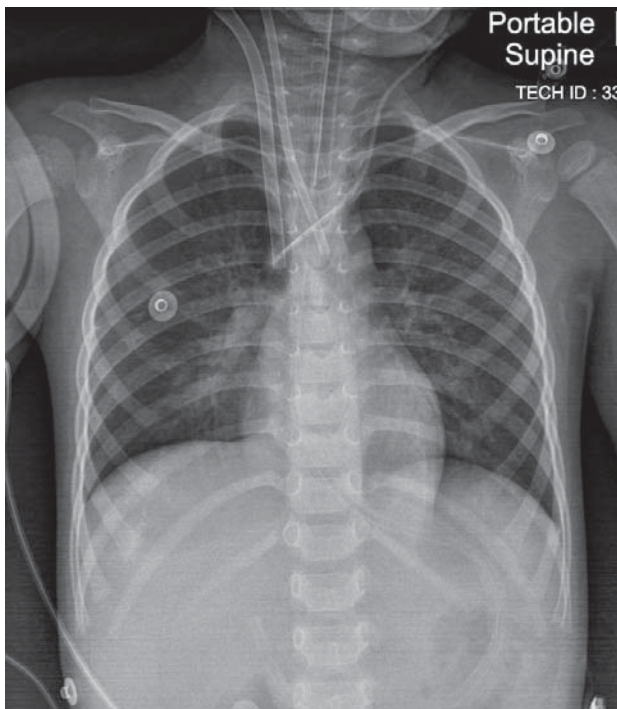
On January 24, 2013 at 15:38, a chest x-ray AP supine position reveals improvement of pulmonary edema.
